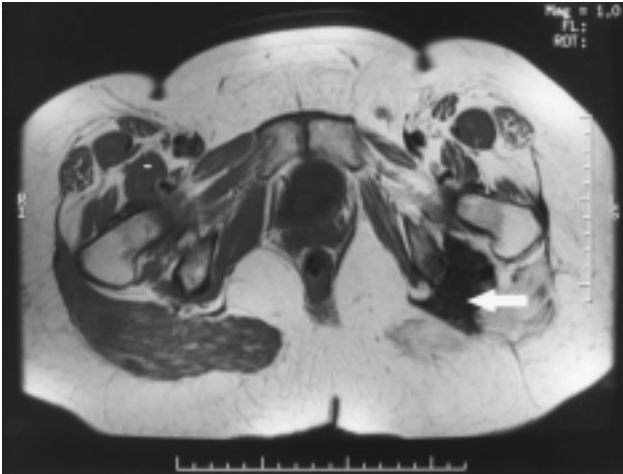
T1-weighted magnetic resonance imaging scan of the patient taken at age 47 years showing no change in desmoid tumour size (arrow) after 14 years of tamoxifen therapy.
